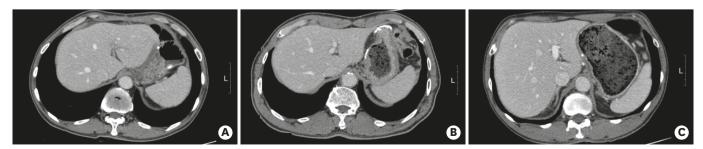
Gastric food retention in computed tomography scans. (A) Grade 0: no food residue in the stomach. (B) Grade 1: presence of food with the stomach rugae preserved. (C) Grade 2: stomach filled with food such that there are no rugae.
